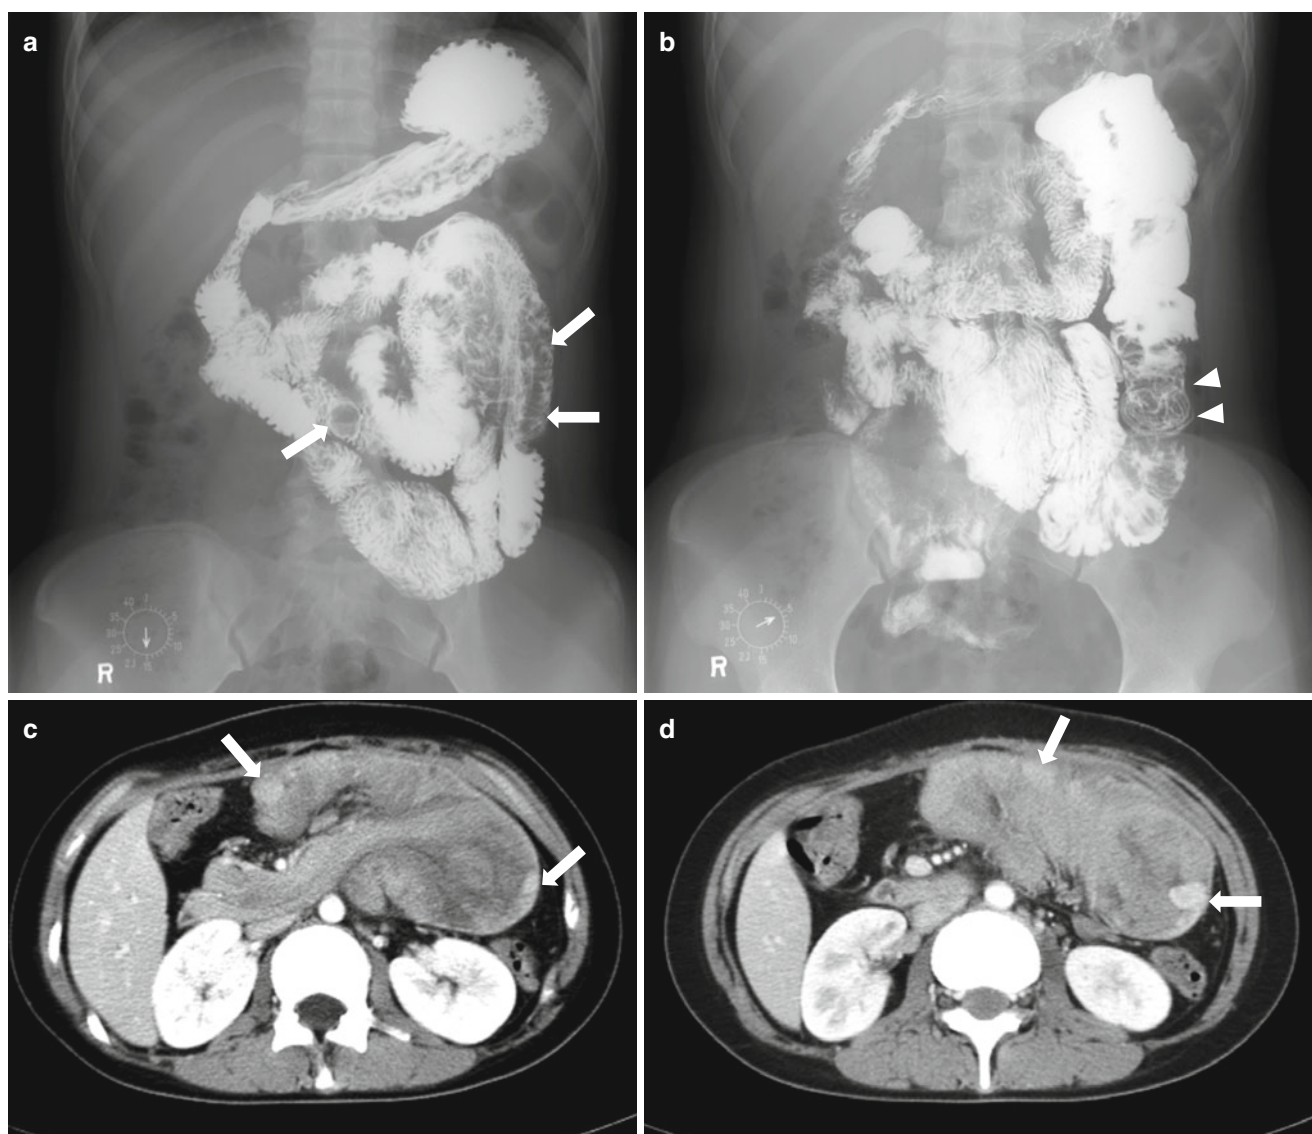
Peutz–Jeghers syndrome. (a, b) Small bowel series show multiple polyps as filling defect in the proximal jejunum (a, arrows). Note the coil spring appearance at proximal jejunum suggesting intussusception (b, arrowheads). (c, d) Axial post-contrast CT of another
